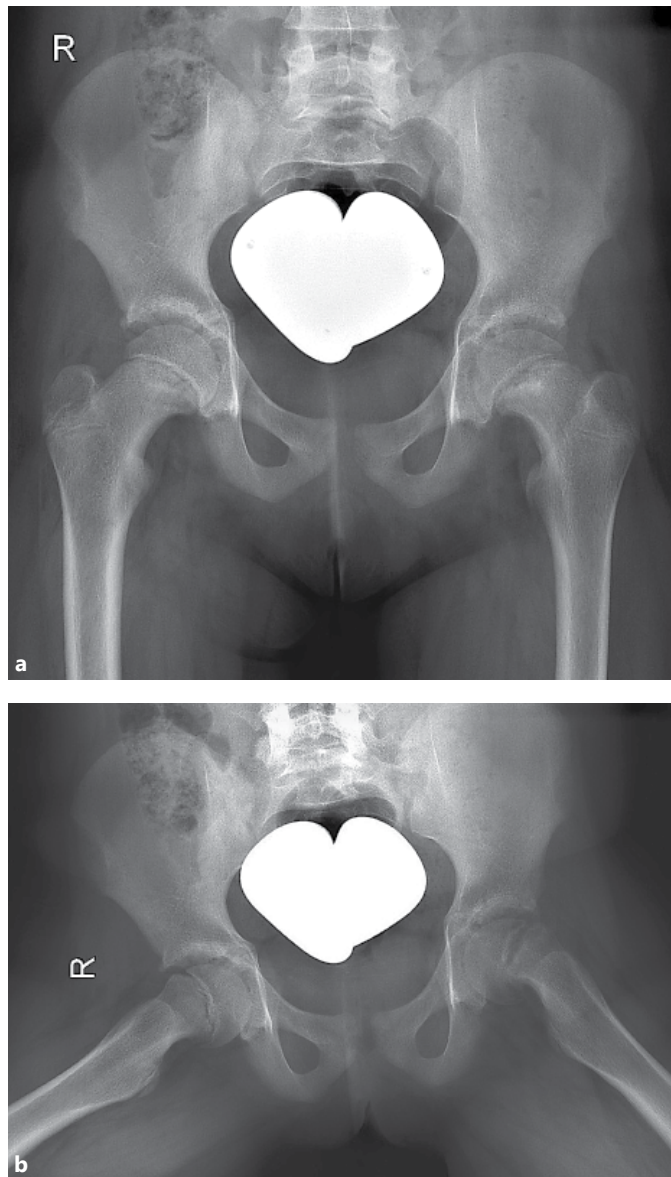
Radiographic diagnosis of SCFE is always performed in 2 projections. In the pelvic overview radiograph (a), only a more severe loosening of the left epiphyseal plate is discernible. Only in the axial view (b), the advanced slippage of the left epiphyseal plate and the incipient dorsal slippage of the right epiphyseal plate are visible. The angle of slippage in each case can be measured.
